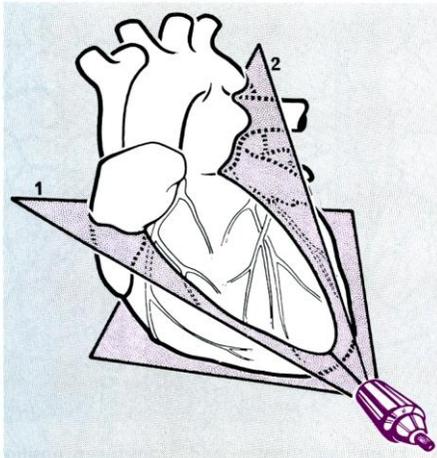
Transducer position and examining planes for apical 2-0 echocardiograms. Plane 1 passes through the four-chamber plane of the heart. Plane 2 represents the path of the ultrasonic beam for the two-chamber apical examination.
